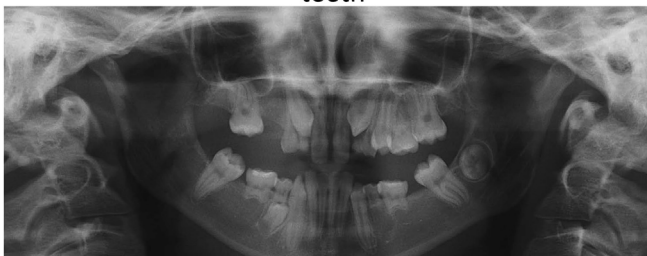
Agensis of teeth related to gene mutation in a child that developed SDB. This simple dental X-rays show the many absent teeth related to mutation. The child has an apnea–hypopnea-index (AHI) of 3.8 with a much higher AHI in rapid-eye-movement-REM-sleep. Flow limitation defined with nasal cannula – pressure transducer, leading to important daytime fatigue and large and abnormal amount of cyclic-alternating pattern with abnormal amount of phase A2 and A3 during non-rapid-eye-movement – NREM-sleep indicative of sleep-disruption, is present during 71% of total sleep time. SDB: sleep-disordered breathing.
